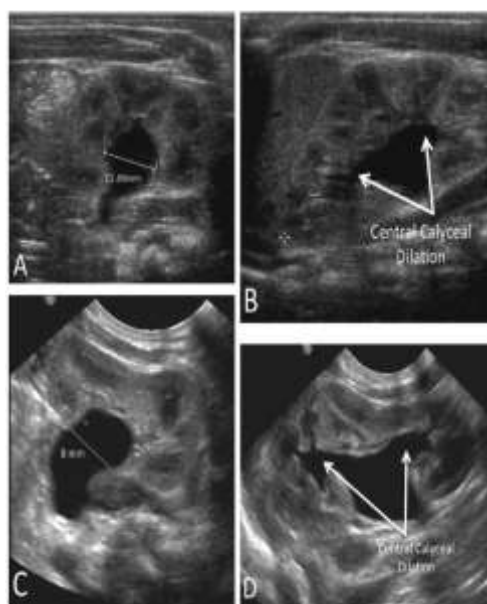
Appearance of UTD P1 on postnatal ultrasound. A: Imaging in the transverse plane demonstrates an anterior-posterior renal pelvis diameter (APRPD) 10 to <15 mm. B: Imaging in the sagittal plane demonstrates central but no peripheral calyceal dilation. The renal parenchyma is otherwise normal. The bladder is normal (not shown), and the ureters are not visualized. Another example of UTD P1 on postnatal US. C: Imaging in the transverse plane demonstrates an APRPD <10 mm. D: However, imaging in the sagittal plane demonstrates central calyceal dilation.
